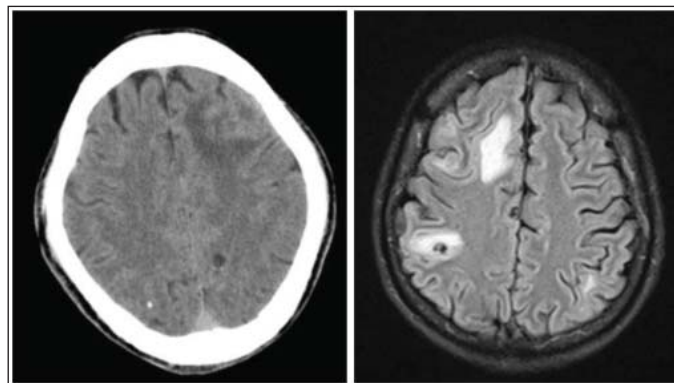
NECT and FLAIR MRI images showing NCC at the vesicular stage and calcified stage with oedema.
